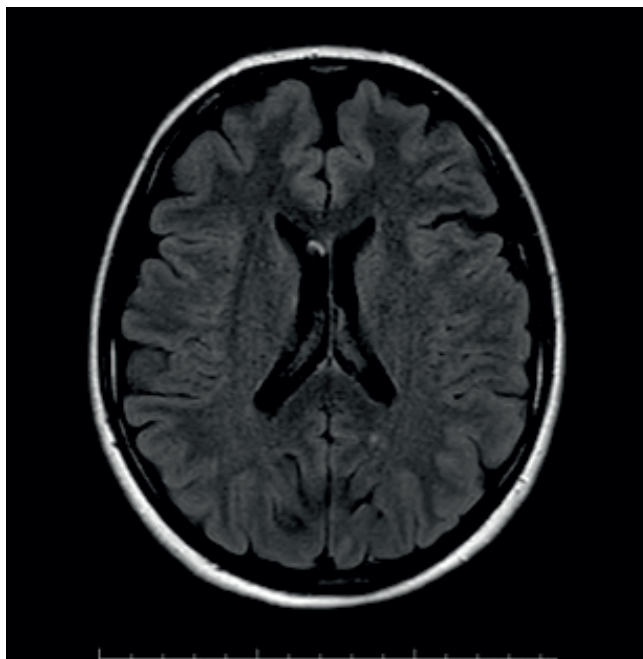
Normal serebral magnetic resonance imaging findings.
